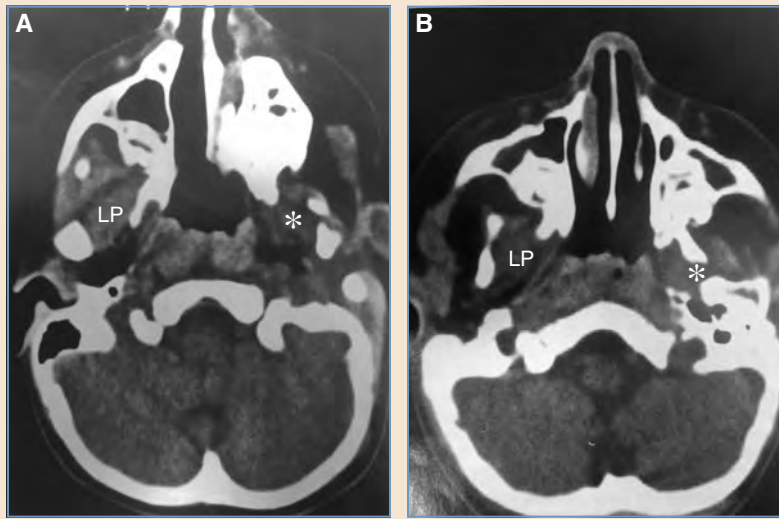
A cross-sectional CT scan reveals the hypoplastic muscle that accompanies the skeletal deformity as it affects the normal origin and insertion. Absence of the zygomatic arch would affect the masseter muscle. Absence of the coronoid would affect the temporalis muscle. Absence of a condyle would affect the lateral pterygoid muscle, as shown in A, Pruzansky grade II and in B, Pruzansky grade III deformities. Absence of the coronoid would affect the temporalis muscle. (*, Affected side; LP, lateral pterygoid muscle.)
